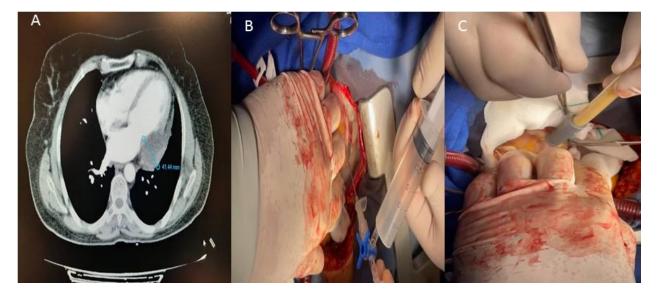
A: In the first case, a CT scan showed a cystic mass at the left side of the heart (blue arrow); B: PAIR, instill of the first case before resection; C: PAIR, aspiration of the first case before resection
